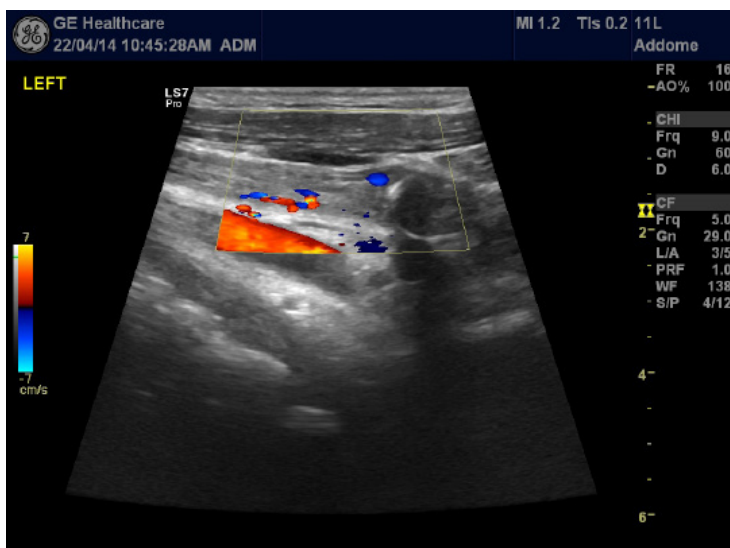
Doppler ultrasonography showing internal jugular vein thrombosis
